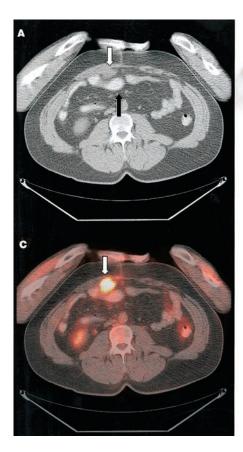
Example of clinical value of oral contrast in patient with resected colorectal carcinoma evaluated with ¹⁸F-FDG PET for suspected recurrence. (A) Transverse CT image shows transverse colon with contrast (white arrow) and soft-tissuedensity lesion adjacent to anterior abdominal wall (black arrow). (B) PET images with CT attenuation correction show focus of intense uptake in anterior abdomen (white arrow). (C) Fused PET/CT image shows that focus of uptake corresponds to soft-tissue mass (white arrow) and not to bowel. Diagnosis of peritoneal tumor implant was made. Patient underwent chemotherapy.
